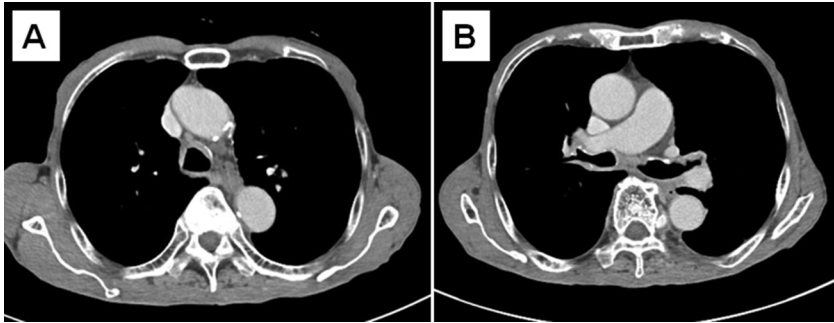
Chest CT shows diffuse irregular wall thickening at the trachea (A) and bilateral bronchi (B).
